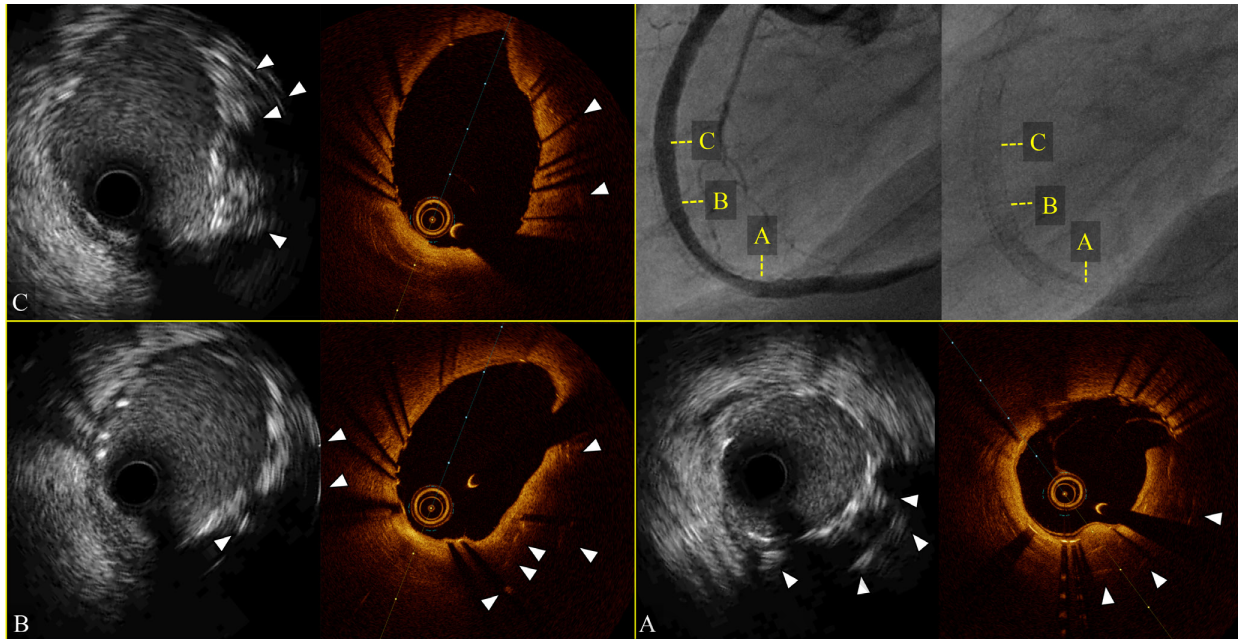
Intravascular ultrasound and optical coherence tomography showing adequate crushing of the occluded stents and optimal expansion and apposition of the newly implanted stents. Arrowheads indicate crushed stent struts.
